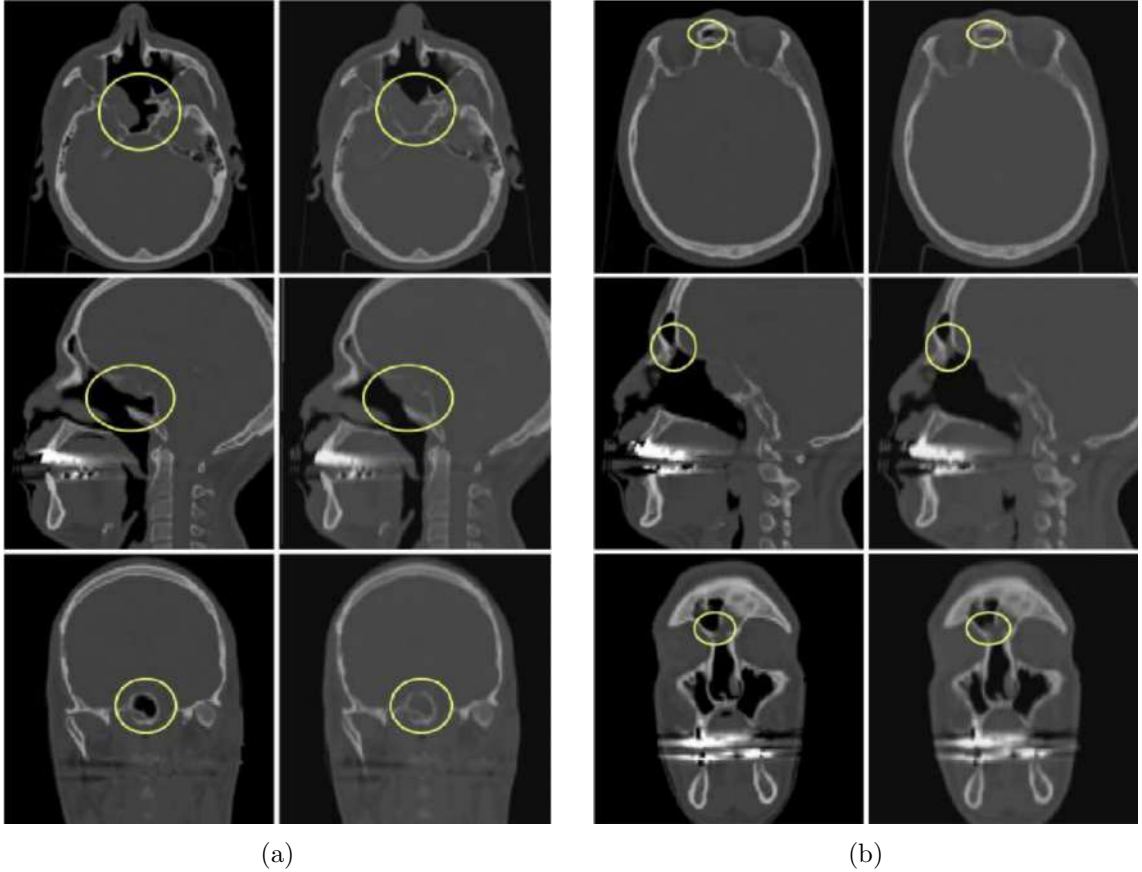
Comparison between the planning CT and the control CT. Left: each row shows the planning CT (first image) and the control CT (second image); the yellow circle highlights the morphological change in the tumor region. Right: the second, smaller morphological change is indicated by the yellow circles. Image adapted from [66].
